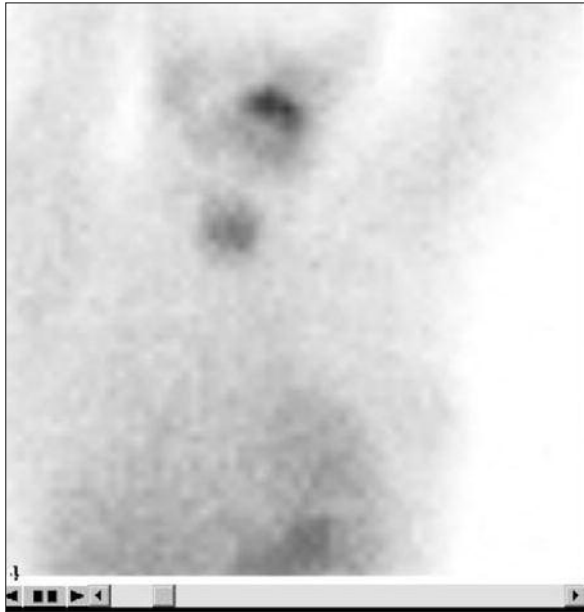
Coronal image from the source data of a ^{99m}Tc -MIBI myocardial scintigraphy shows a thyroid gland uptake.
